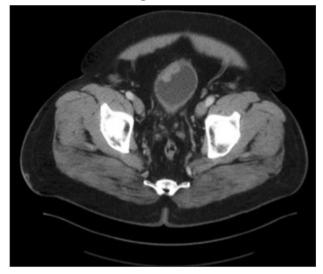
Abdominal axial CT showing cT1 nested variant.
